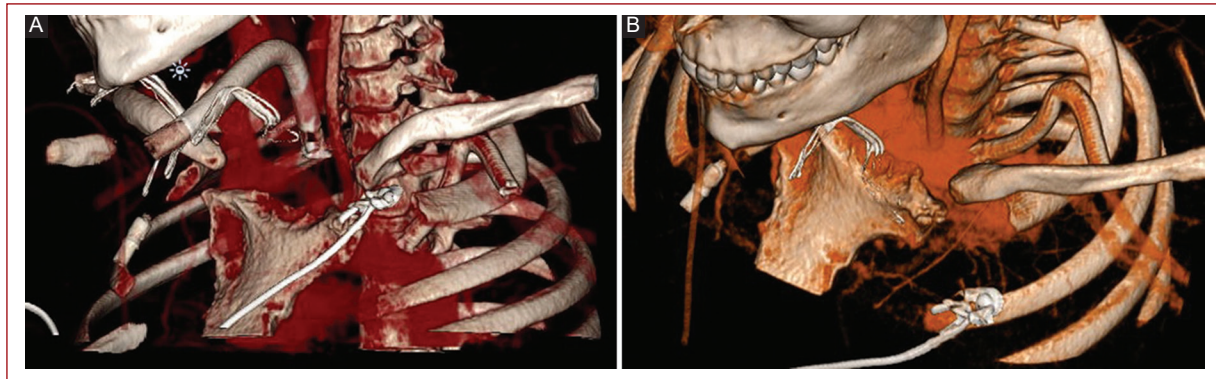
A and B: 3D Reconstruction of control computed tomography scan 2 months after spontaneous left subclavian artery rupture. Correct placement of the stent with no new vascular events.
